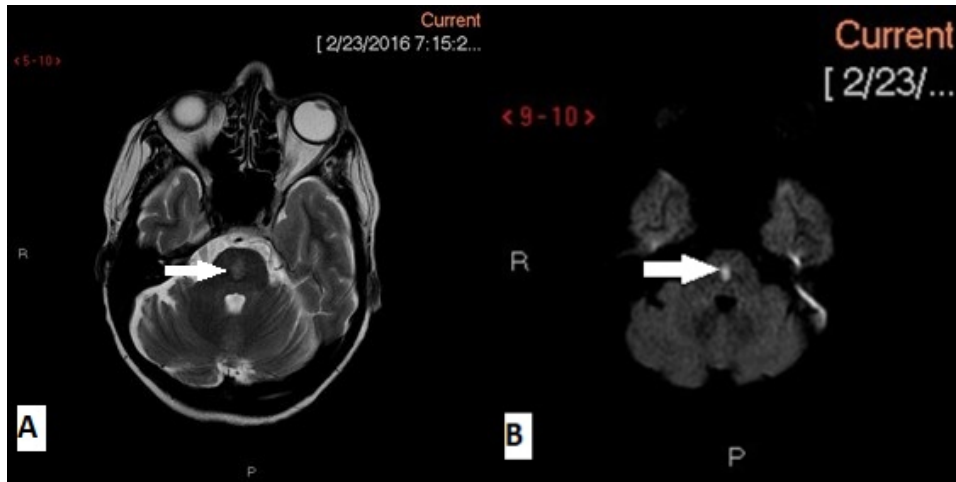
(A, B): Axial T2-weighted/DWI images show minor high T2 and diffusion restriction abnormality in the central pons
